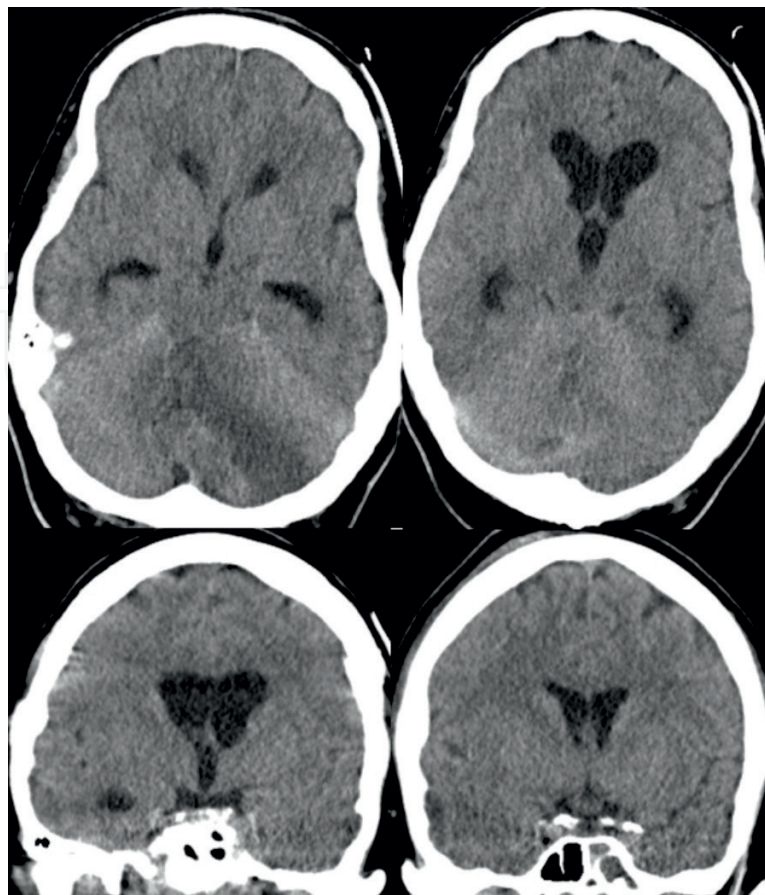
Obstructive hydrocephalus in case of cerebellar infarct (left above and below) preoperative CT scan—dilatation of temporal horn and frontal horn of lateral ventricle and third ventricle (right above and below) postoperative CT scan, reduced size of ventricle system.
